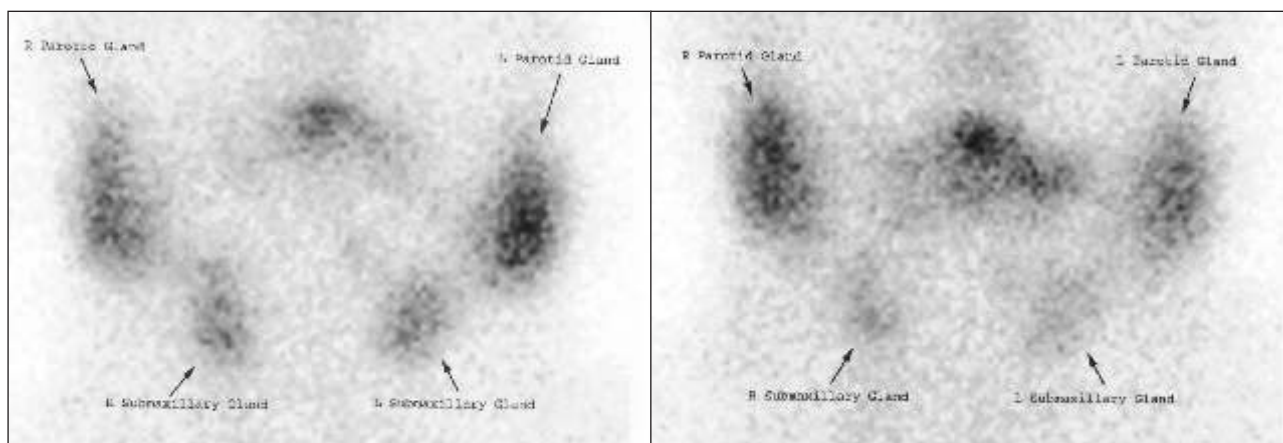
Tc-99m Pertechnetate sialoscintigraphy performed before (A) and after (B) oral administration of lemon juice. Study shows poor washout of radiotracer from right parotid gland following oral administration of lemon juice.
